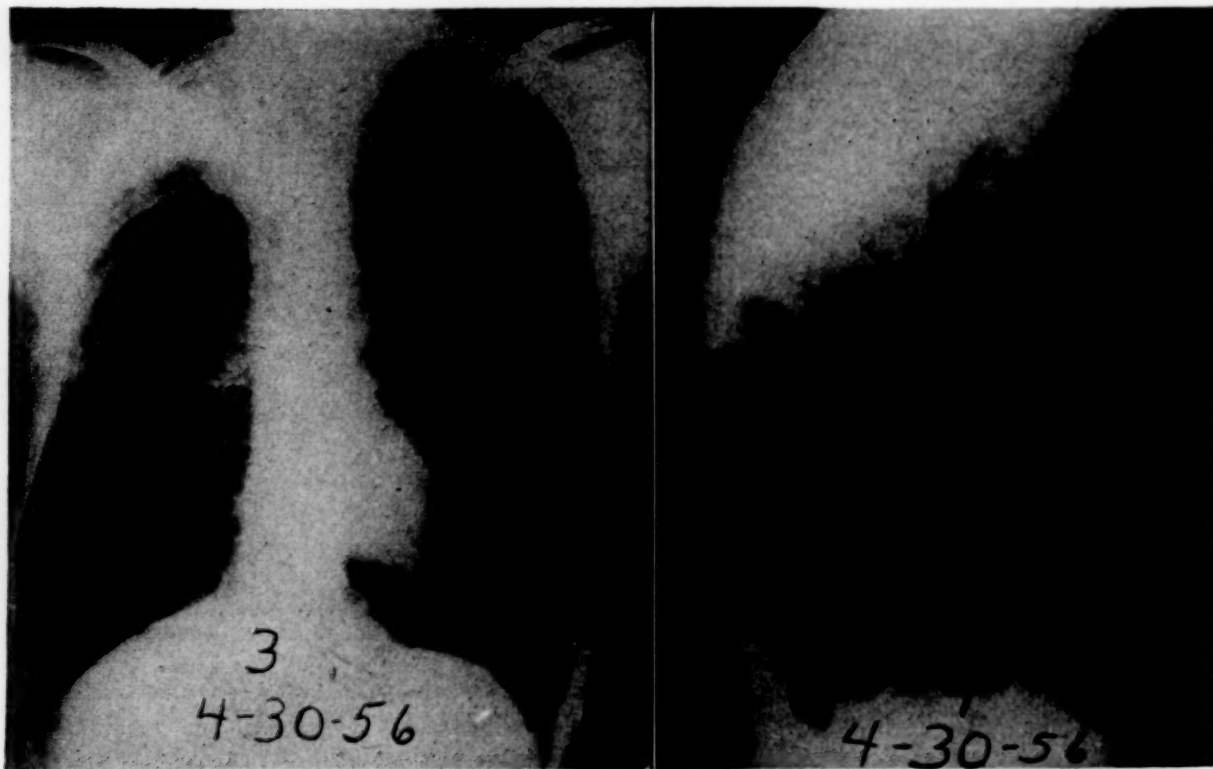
CASE IX. Postoperative roentgenograms showing small residual pneumoperitoneum.
